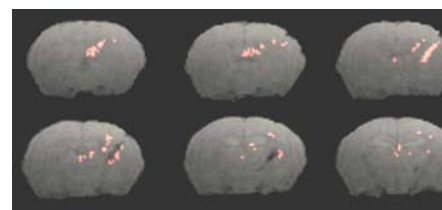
Overlay of differences found between MRI at day seven after injection and preinjection MRI in slices near the injection of HIV infected human macrophages.
